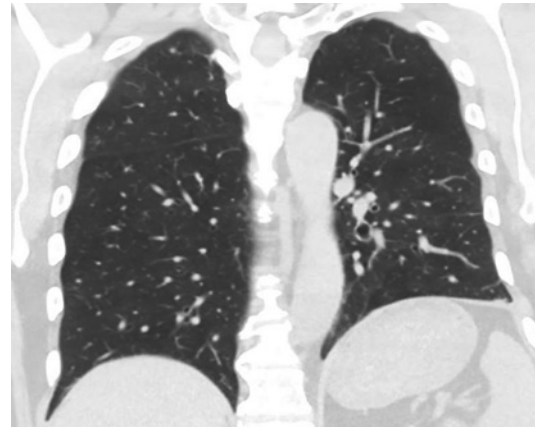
CT scan showing innumerable pulmonary nodules and irregular nodular opacities throughout the lungs. CT, computed tomography.
